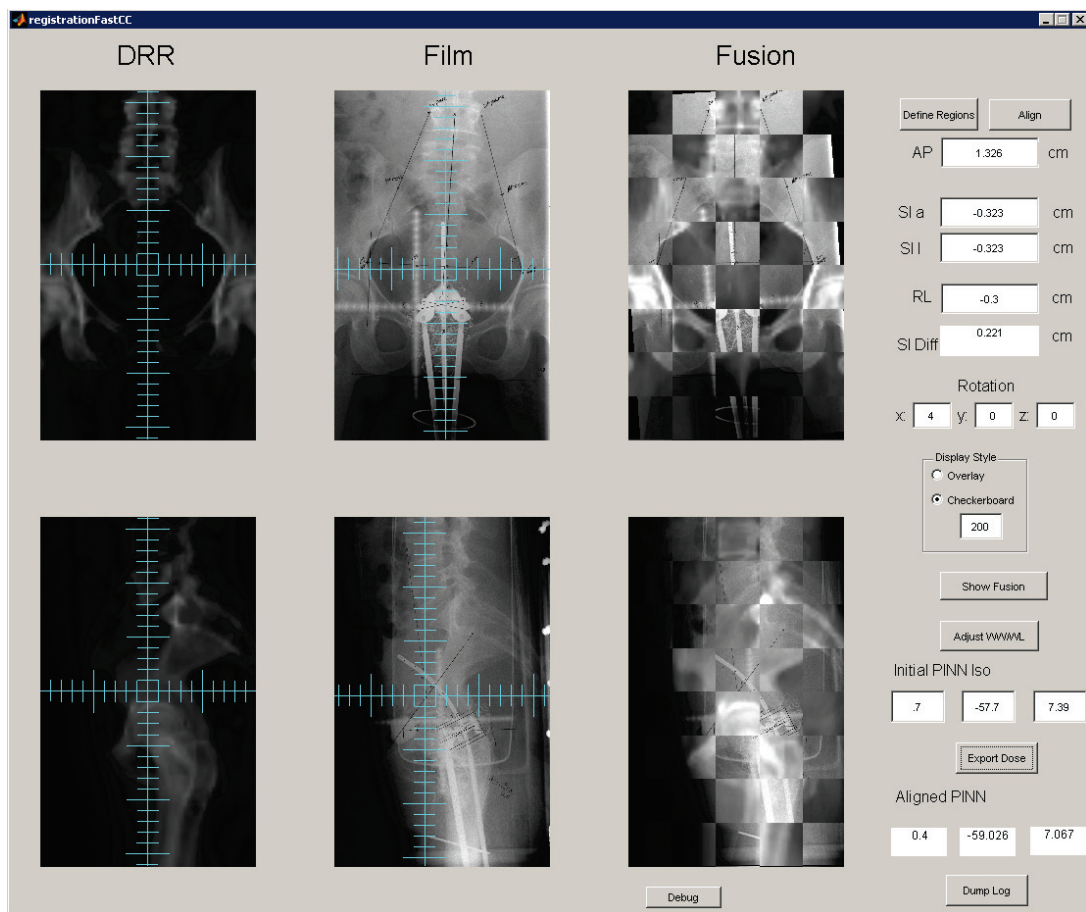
User interface created in-house using MATLAB for aligning digitally reconstructed radiographs (DRRs) and film images. Auto-alignment results can be verified manually by using the graticules and fusion display.
